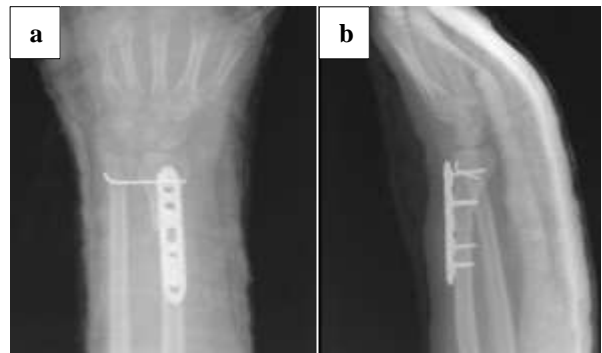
(a) Antero-posterior and (b) lateral view from wrist radiograph after reconstruction.
